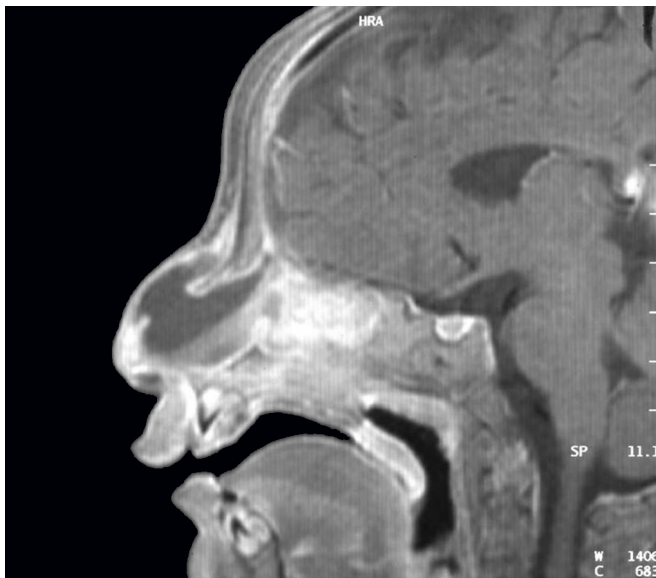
4: MRI showing large prenasal and intranasal encephalocele.
